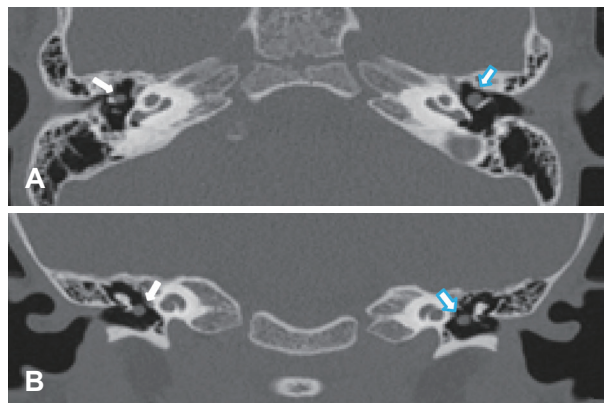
Axial view (A) and coronal view (B) of CT scan shows bilateral round mass in both middle ear cavity. The mass were observed at same level in CT scan, and they were symmetrically located in anterior medial part of malleus. Right mass (white arrow) was 2.5×3 mm and left mass (blue arrow) was 3.5×3 mm sized. CT, computed tomography.
